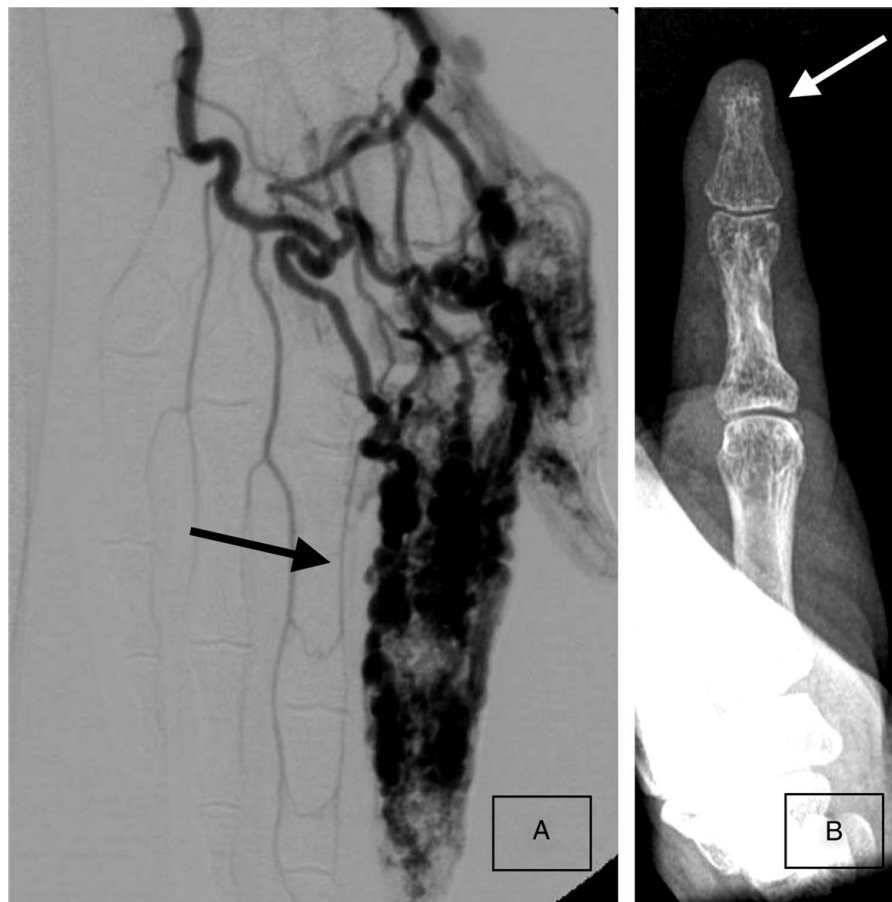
Radiological imaging of the left index finger in 1997. (A) Computed tomography angiography shows the presence of arteriovenous malformations. (B) Radiograph showing bone destruction at the tip of the index finger and affected bone.
